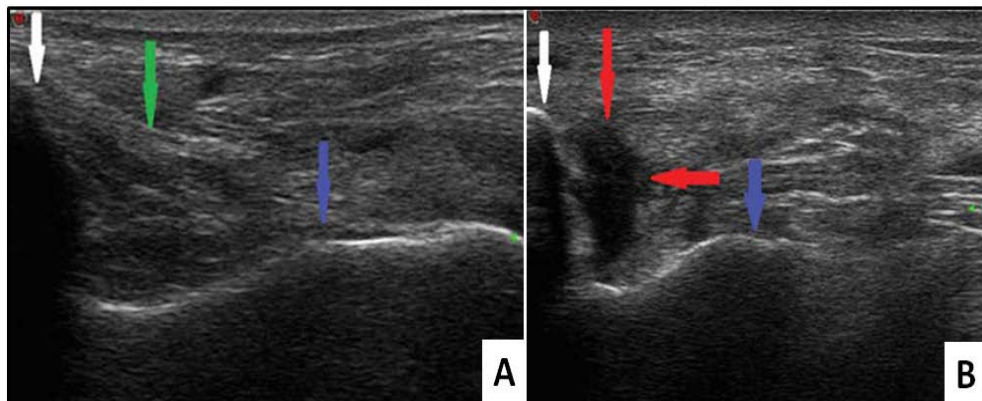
Ultrasonography showing intact (A) and disrupted (B) deltoid ligaments: white arrow, medial malleolus of the tibia; blue arrow, talus; green arrow, intact deltoid; red arrows, injured deltoid (modified from Henari et al., 2011).
